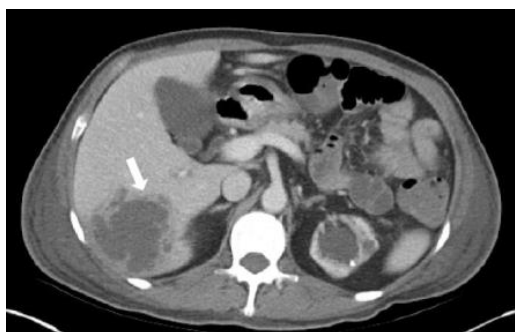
Post-contrast CT showing a large low attenuated mass-like lesion(arrow) in right lobe of liver suggesting liver abscess.
